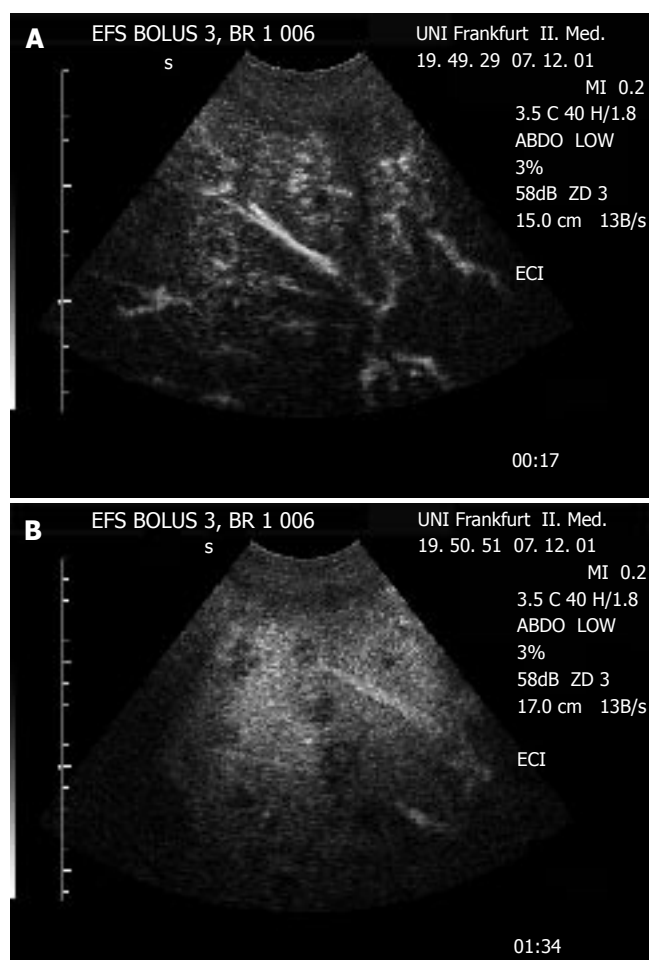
Detection of multiple metastatic lesions in the liver of a patient with sarcoma. A: In contrast-enhanced sonography, the lesions show a periperal enhancement in the arterial phase ("rim sign"), indicating the arterial blood supply to the peripheral proliferation zone of this metastatic lesions from a hypervascular tumor. B: During portal-venous phase, the lesions show lack of portal-venous enhancement ('black spot'), indication the absence of portal-venous blood flow typical for malignant liver lesions.
